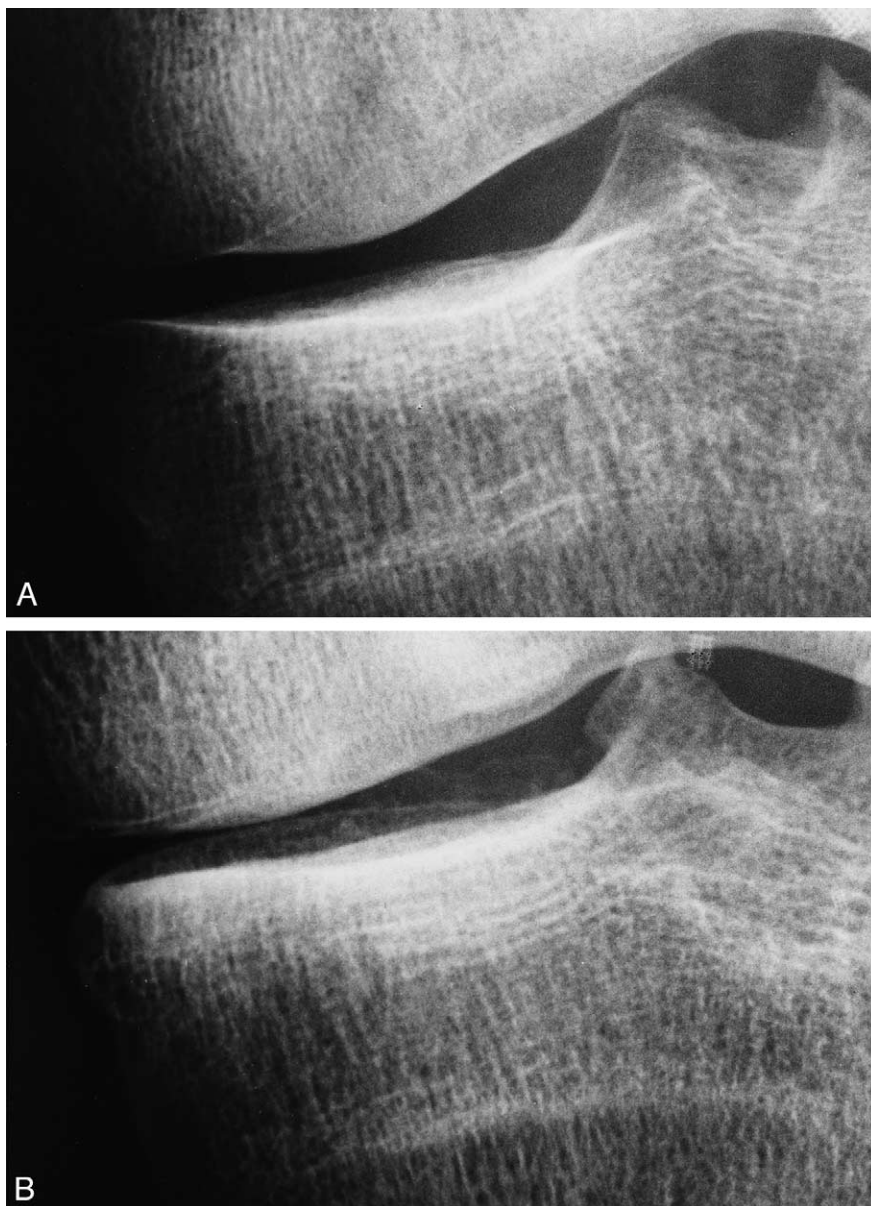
Part of the macroradiographs of the medial compartment of osteoarthritic knees with (A) early disease, characterized by JSW >3 mm and (B) definite disease, characterized by JSW <3 mm. Radiograph of knee with definite disease (B) shows the increase in thickness of the subchondral cortical plate and subjacent horizontal trabeculae resulting in a ladder-like appearance. Original magnification $\times 5$, reproduced $\times 3.2$.
